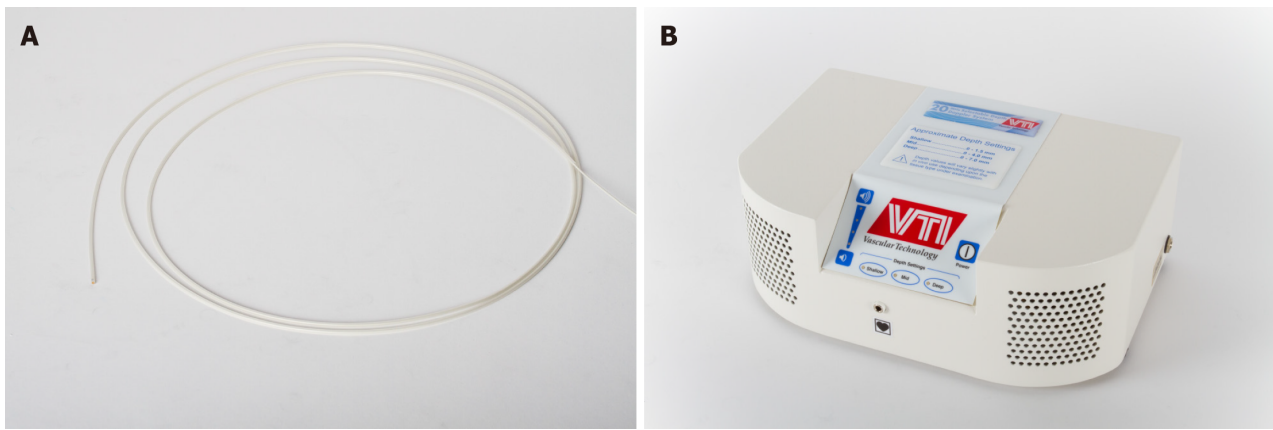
The endoscopic doppler probe. The VTI Selectable Depth Doppler System (created by Vascular Technology, Inc., Nashua, New Hampshire) consists of. A: A single-use 2.5 mm diameter doppler probe; B: A portable AC-powered base unit. Photo courtesy of Vascular Technology, Incorporated. Citation: Vascular Technology, Incorporated. Photo of VTI's Endoscopic Doppler System and Probe. Copyright©Vascular Technology.
